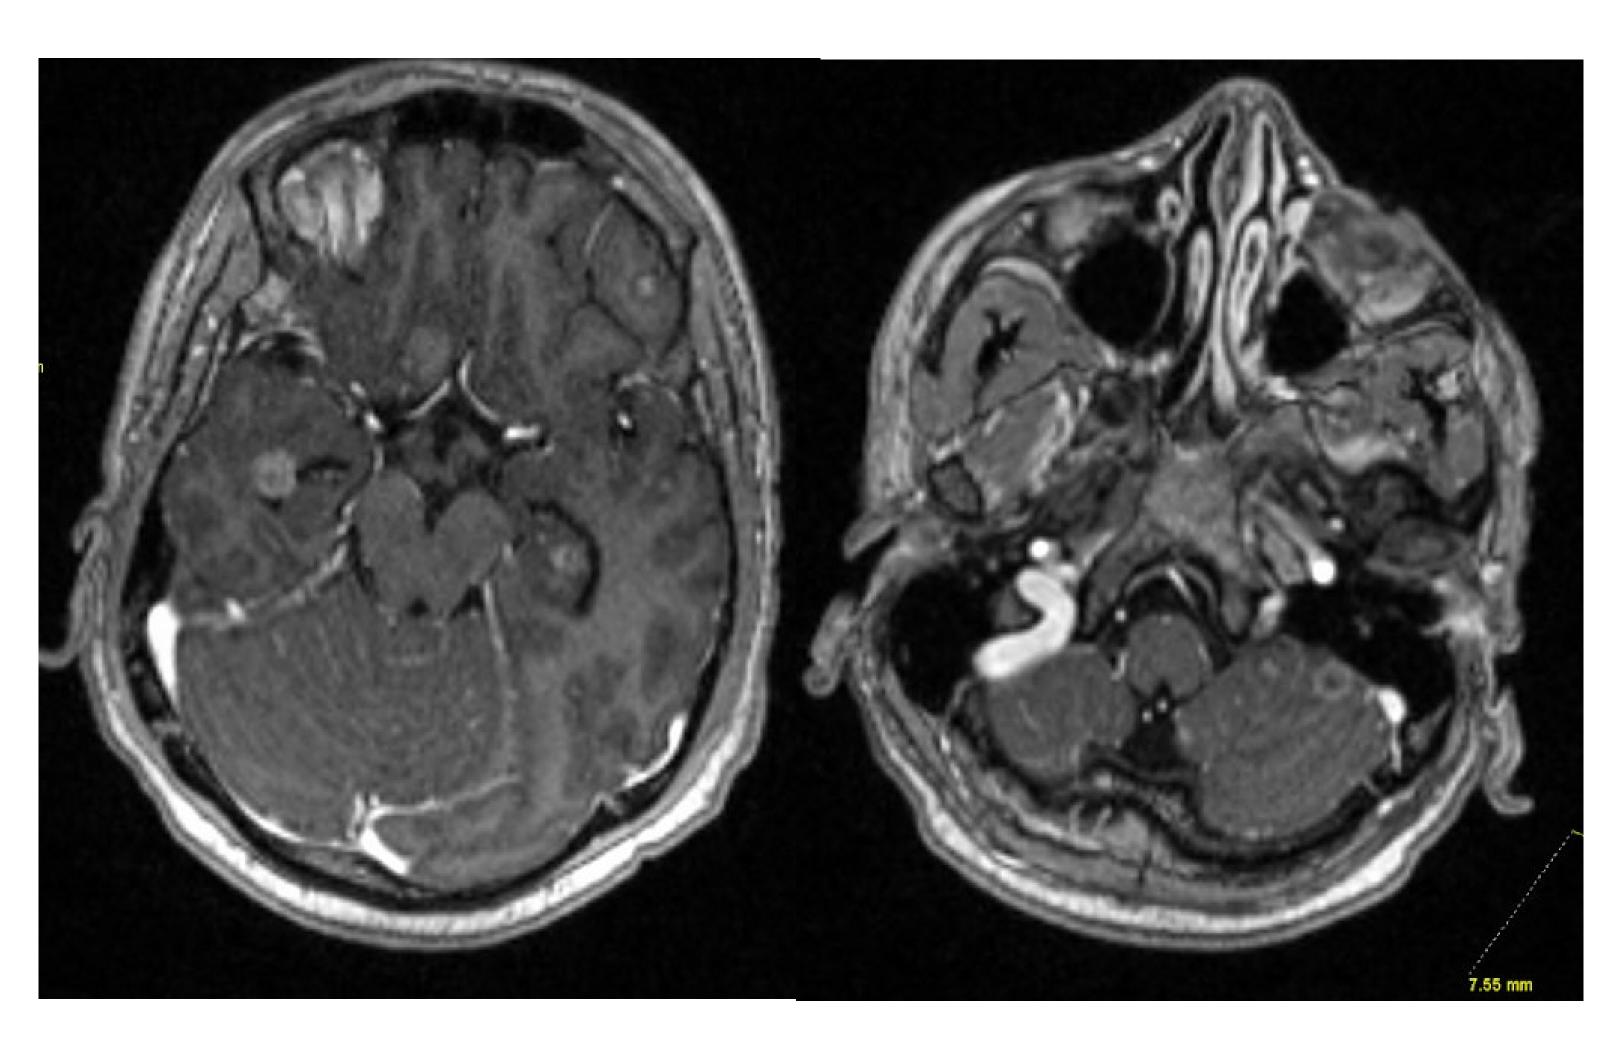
Axial post contrast brain MRI images showing multiple enhancing supratentorial and infratentorial lesions.
